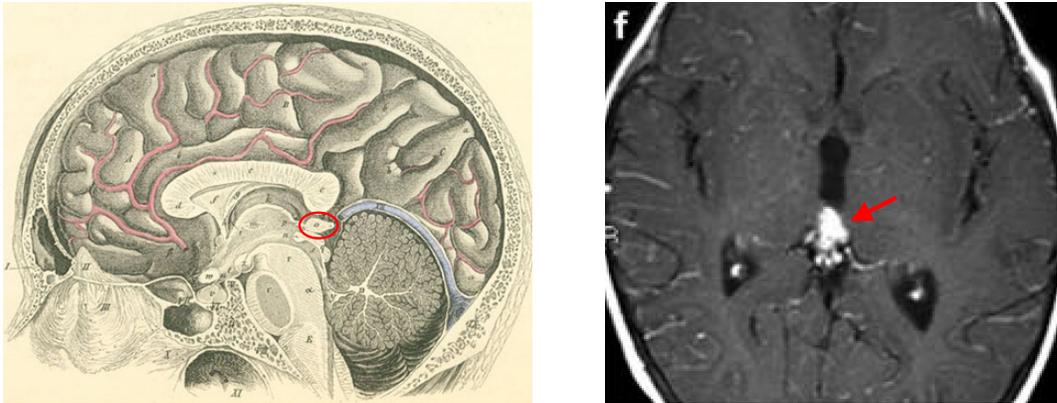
Left*, location of the pineal gland in the center of the brain (from Bock's *Handbuch der Anatomie des Menschen* (1841) Leipzig, Germany, with red oval added). *Right*, nuclear magnetic resonance image of a retinoblastoma tumor of the pineal gland (from (De Ioris et al., 2014) with arrow added).
